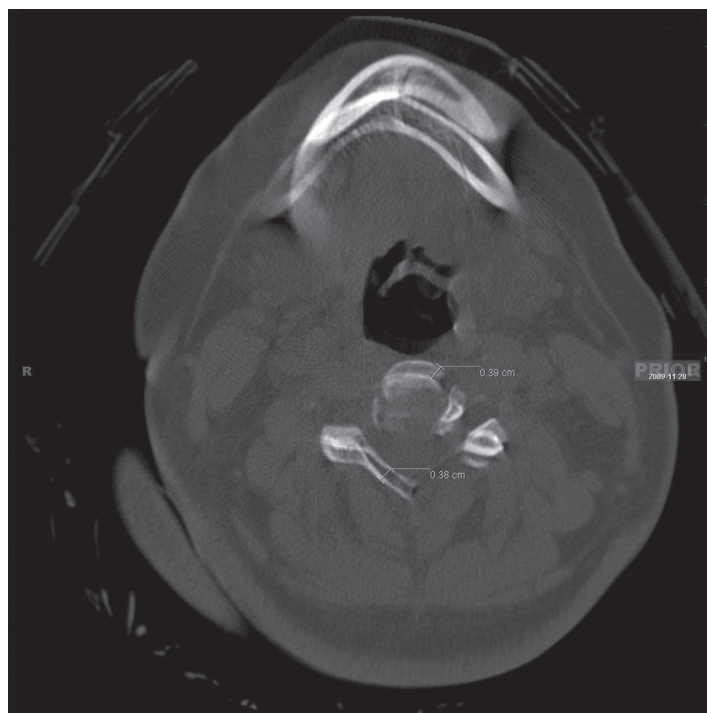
Axial image from the computed tomography at C3-C4.
